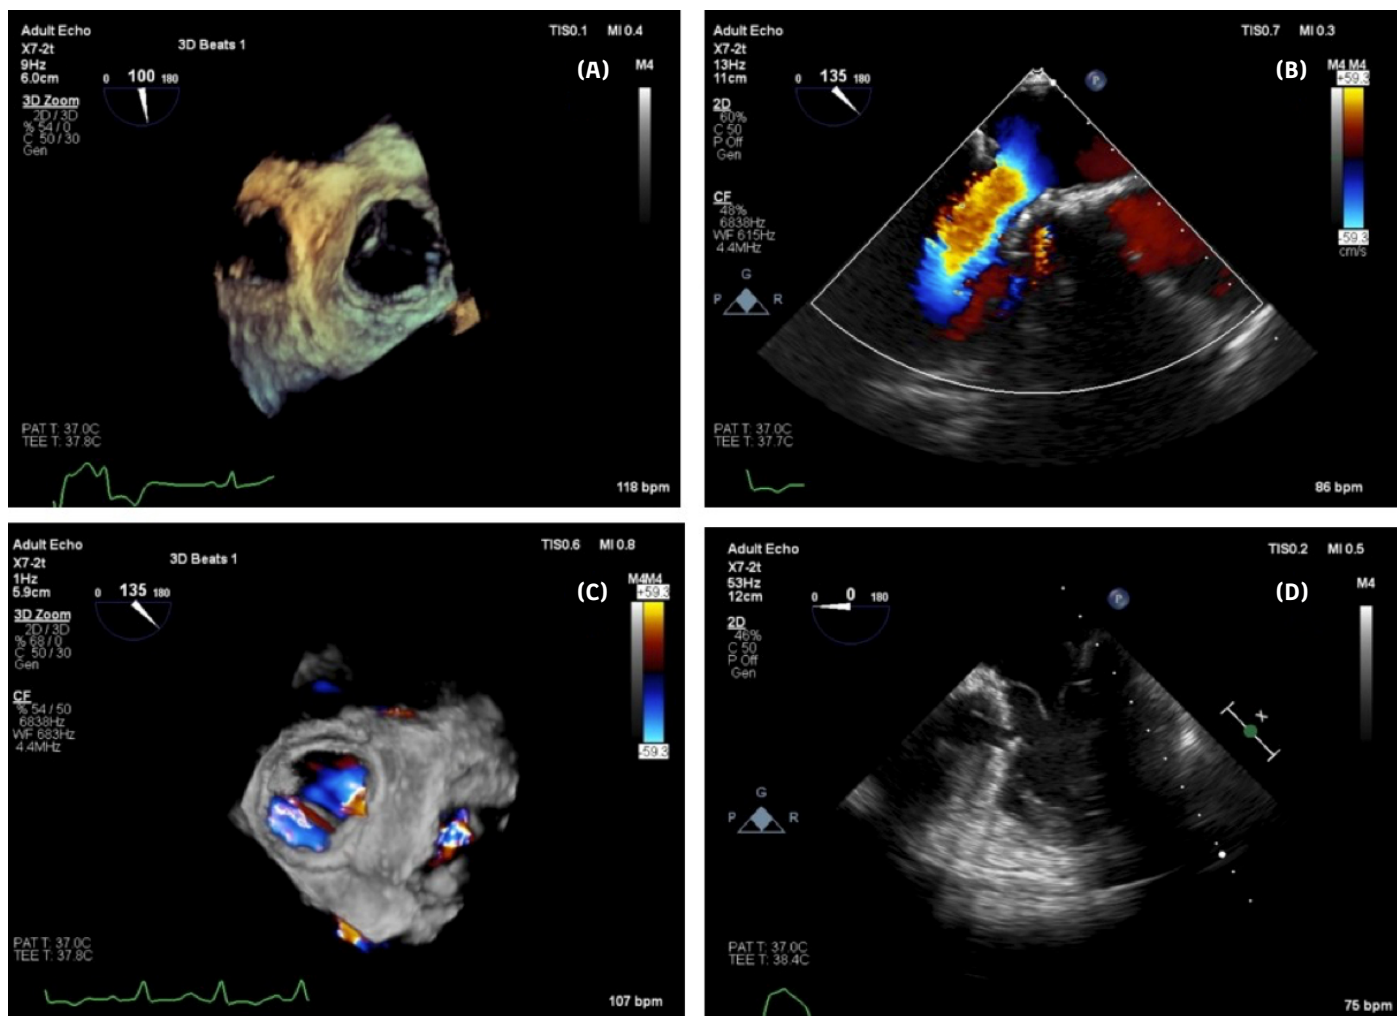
(A) Three-dimensional (3D) transesophageal echocardiography (TEE) image showing a well-functioning 30.5 mm Myval valve. (B) Color Doppler two-dimensional (2D) TEE image showing no paravalvular leak. (C) Color Doppler three-dimensional TEE image showing no paravalvular leak. (D) Two-dimensional TEE image showing a well-functioning 30.5 Myval valve.
